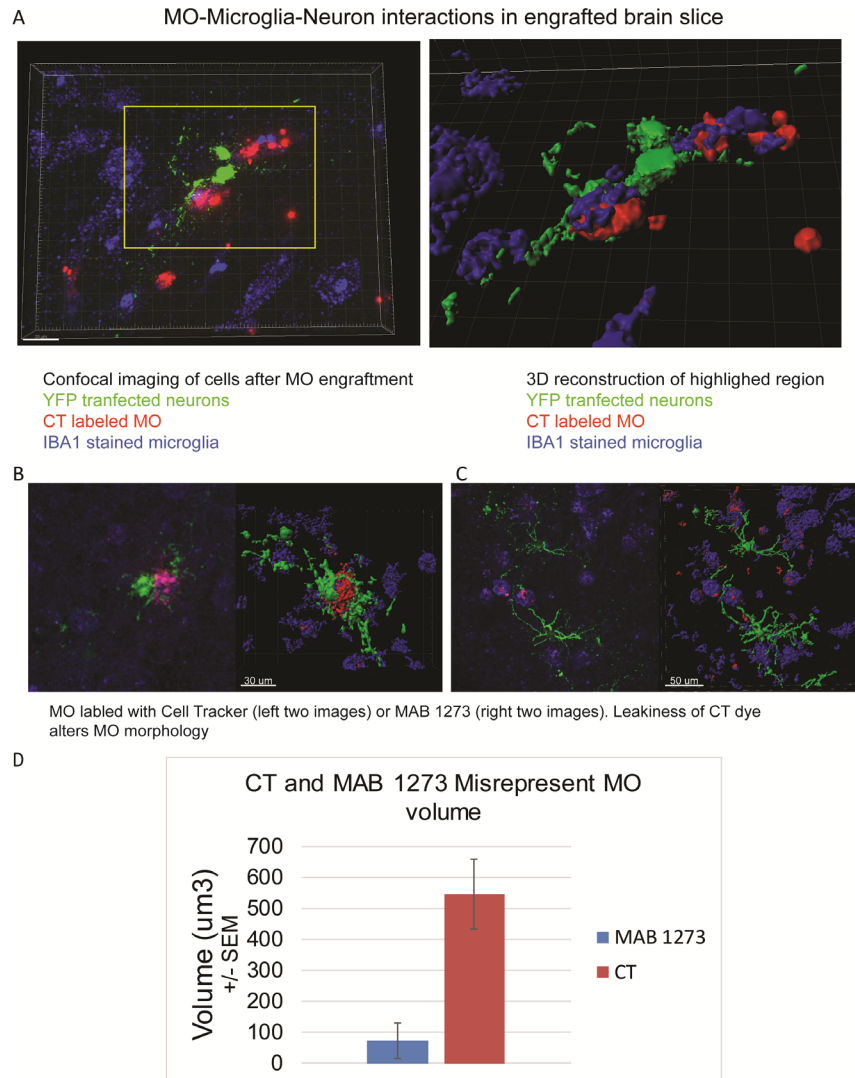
Leakage of CellTracker dye (CT) from MO compromises 3D reconstruction of MO morphologies.
